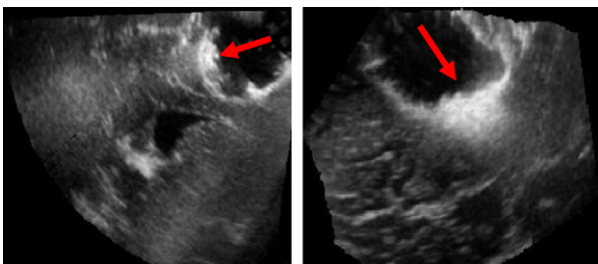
Ultrasound image showing artifact caused by the presence of Surgicel in the resection cavity.
